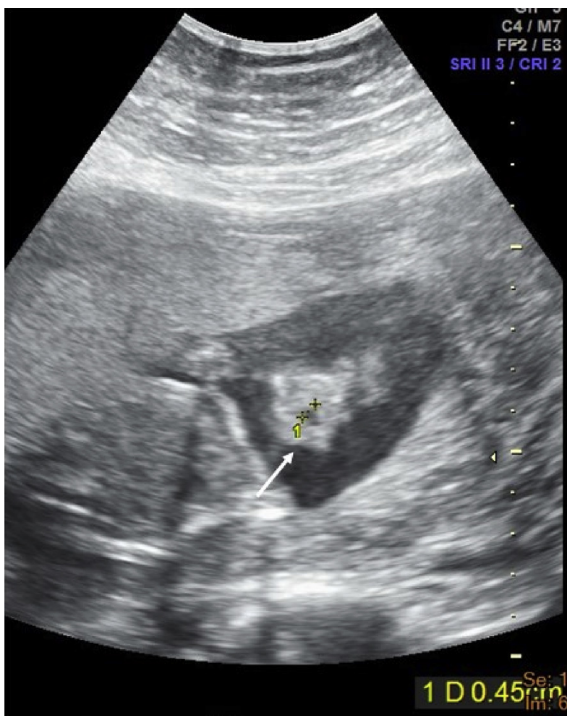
Prenatal ultrasound at 22 weeks of gestation shows median facial cleft (arrow).
